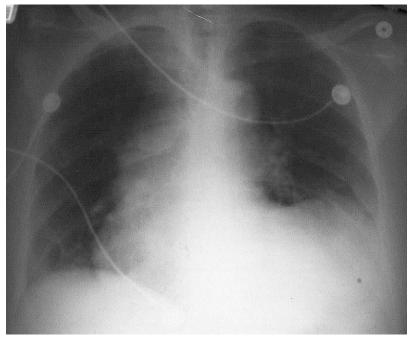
Chest X-ray: wide mediastinum, cardiomegaly, abnormal contour left ventricle and blunting of the left costophrenic angle.
